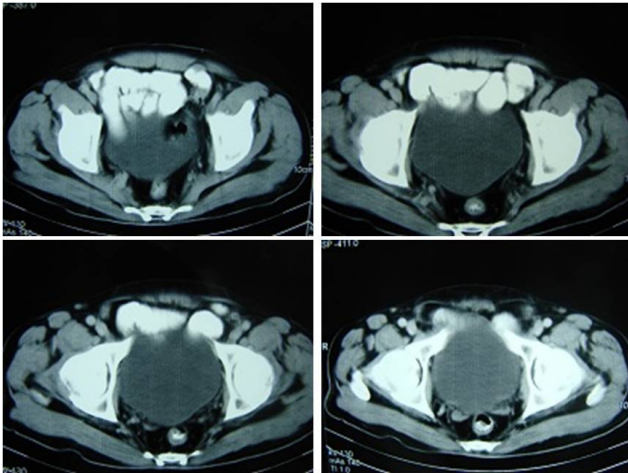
Abdominal CT scan demonstrates that the bowel loops can be seen anterior to the urinary bladder even in the distended state. Note that the bowel loops are reaching up to the level of symphysis pubis.
